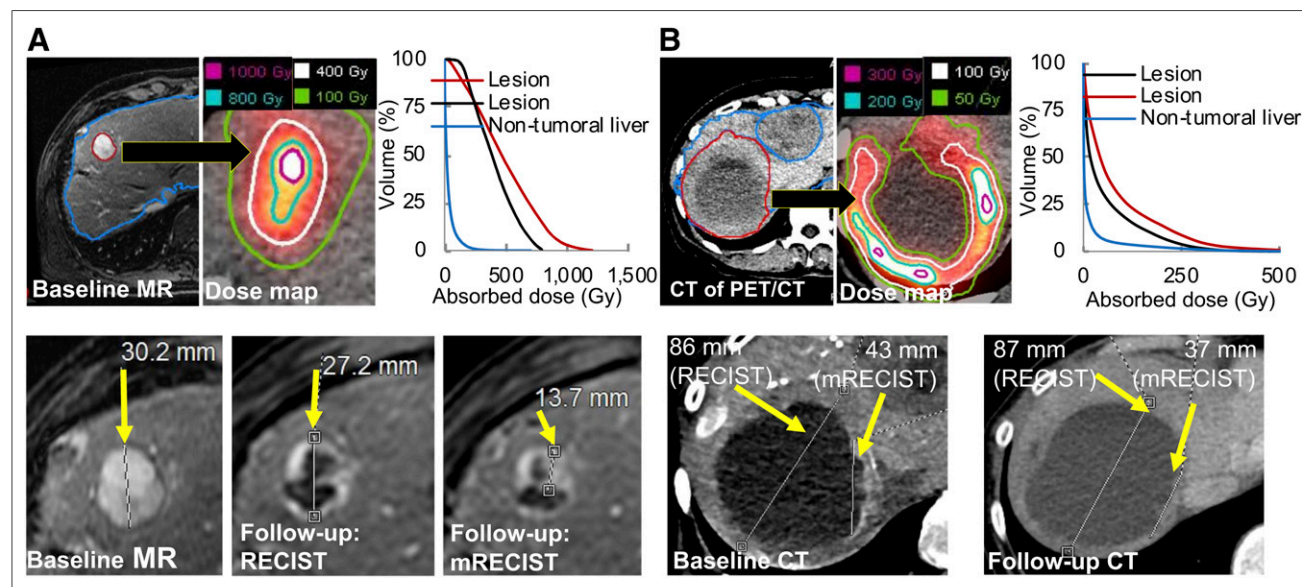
Two patient examples showing lesion and nontumoral liver segmentation on baseline MR (A) or CT of PET/CT (B). PET/CT-derived dose maps with isodose contours and dose–volume histograms (top row) and RECIST/mRECIST-based response assessment (bottom row) are also shown. In A, lesion-level classification was stable disease (nonresponding) according to RECIST but partial response (responding) according to mRECIST. In B, classification was stable disease according to both criteria. Not all lesions are shown.
